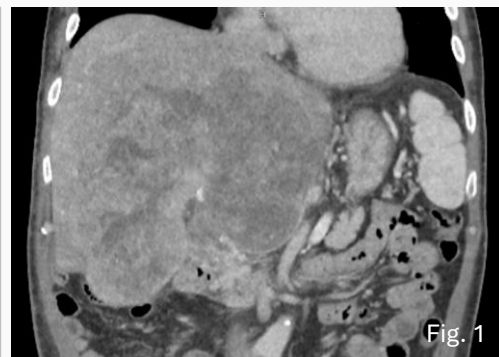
CT showing huge HCC; (2) Catheter angiogram shows two dominant arterial feeders to the tumour; (3) & (4) Simultaneous selective microcatheters placement in the two feeders
